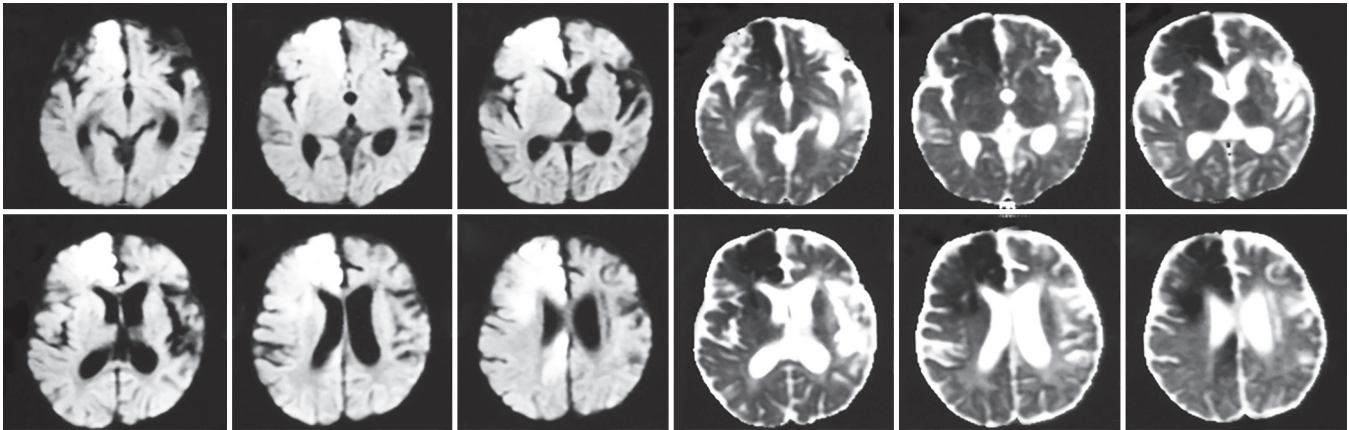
Magnetic resonance imaging (MRI): acute infarct in right inferior parietal gyrus, right corona radiata, right insula, and basal ganglia
